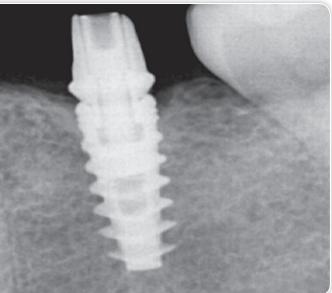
Healing abutment& IOPA Radiograph of the implant placed
